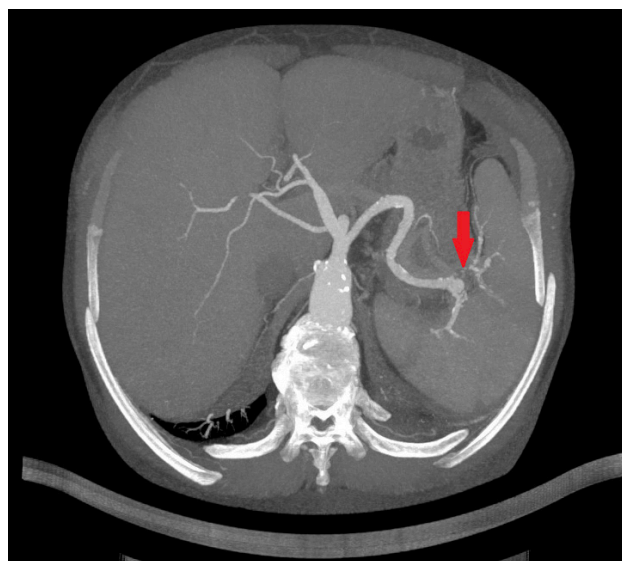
Transversal plane of a CT angiography of the aorta showing a septic embolization of the spleen.
